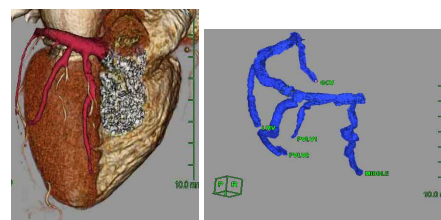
Volume rendering reconstruction of the coronary veins by A) MDCT (left) B) MRI (right)
